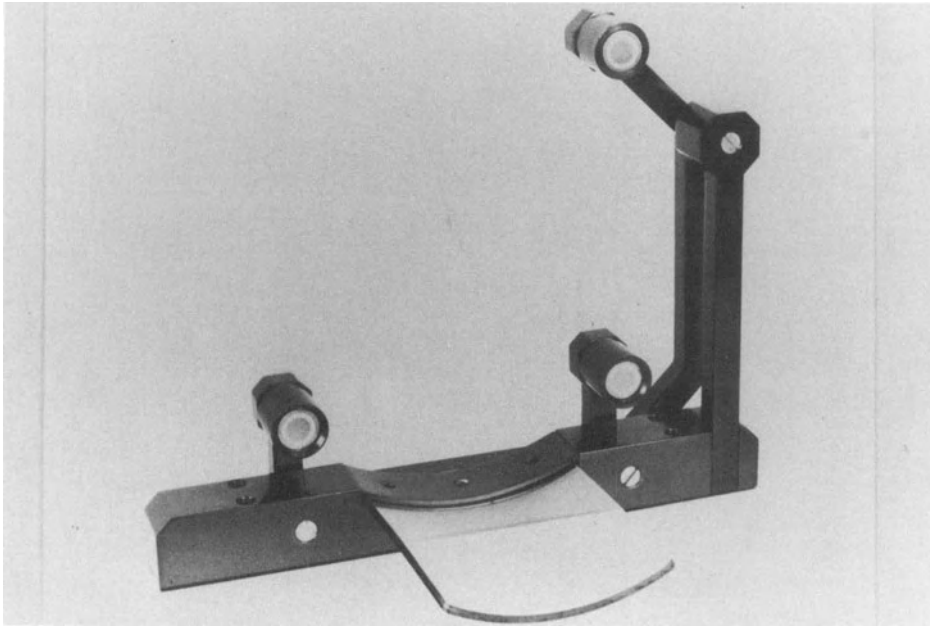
The CT adapter for anchoring the frame to the CT table.
